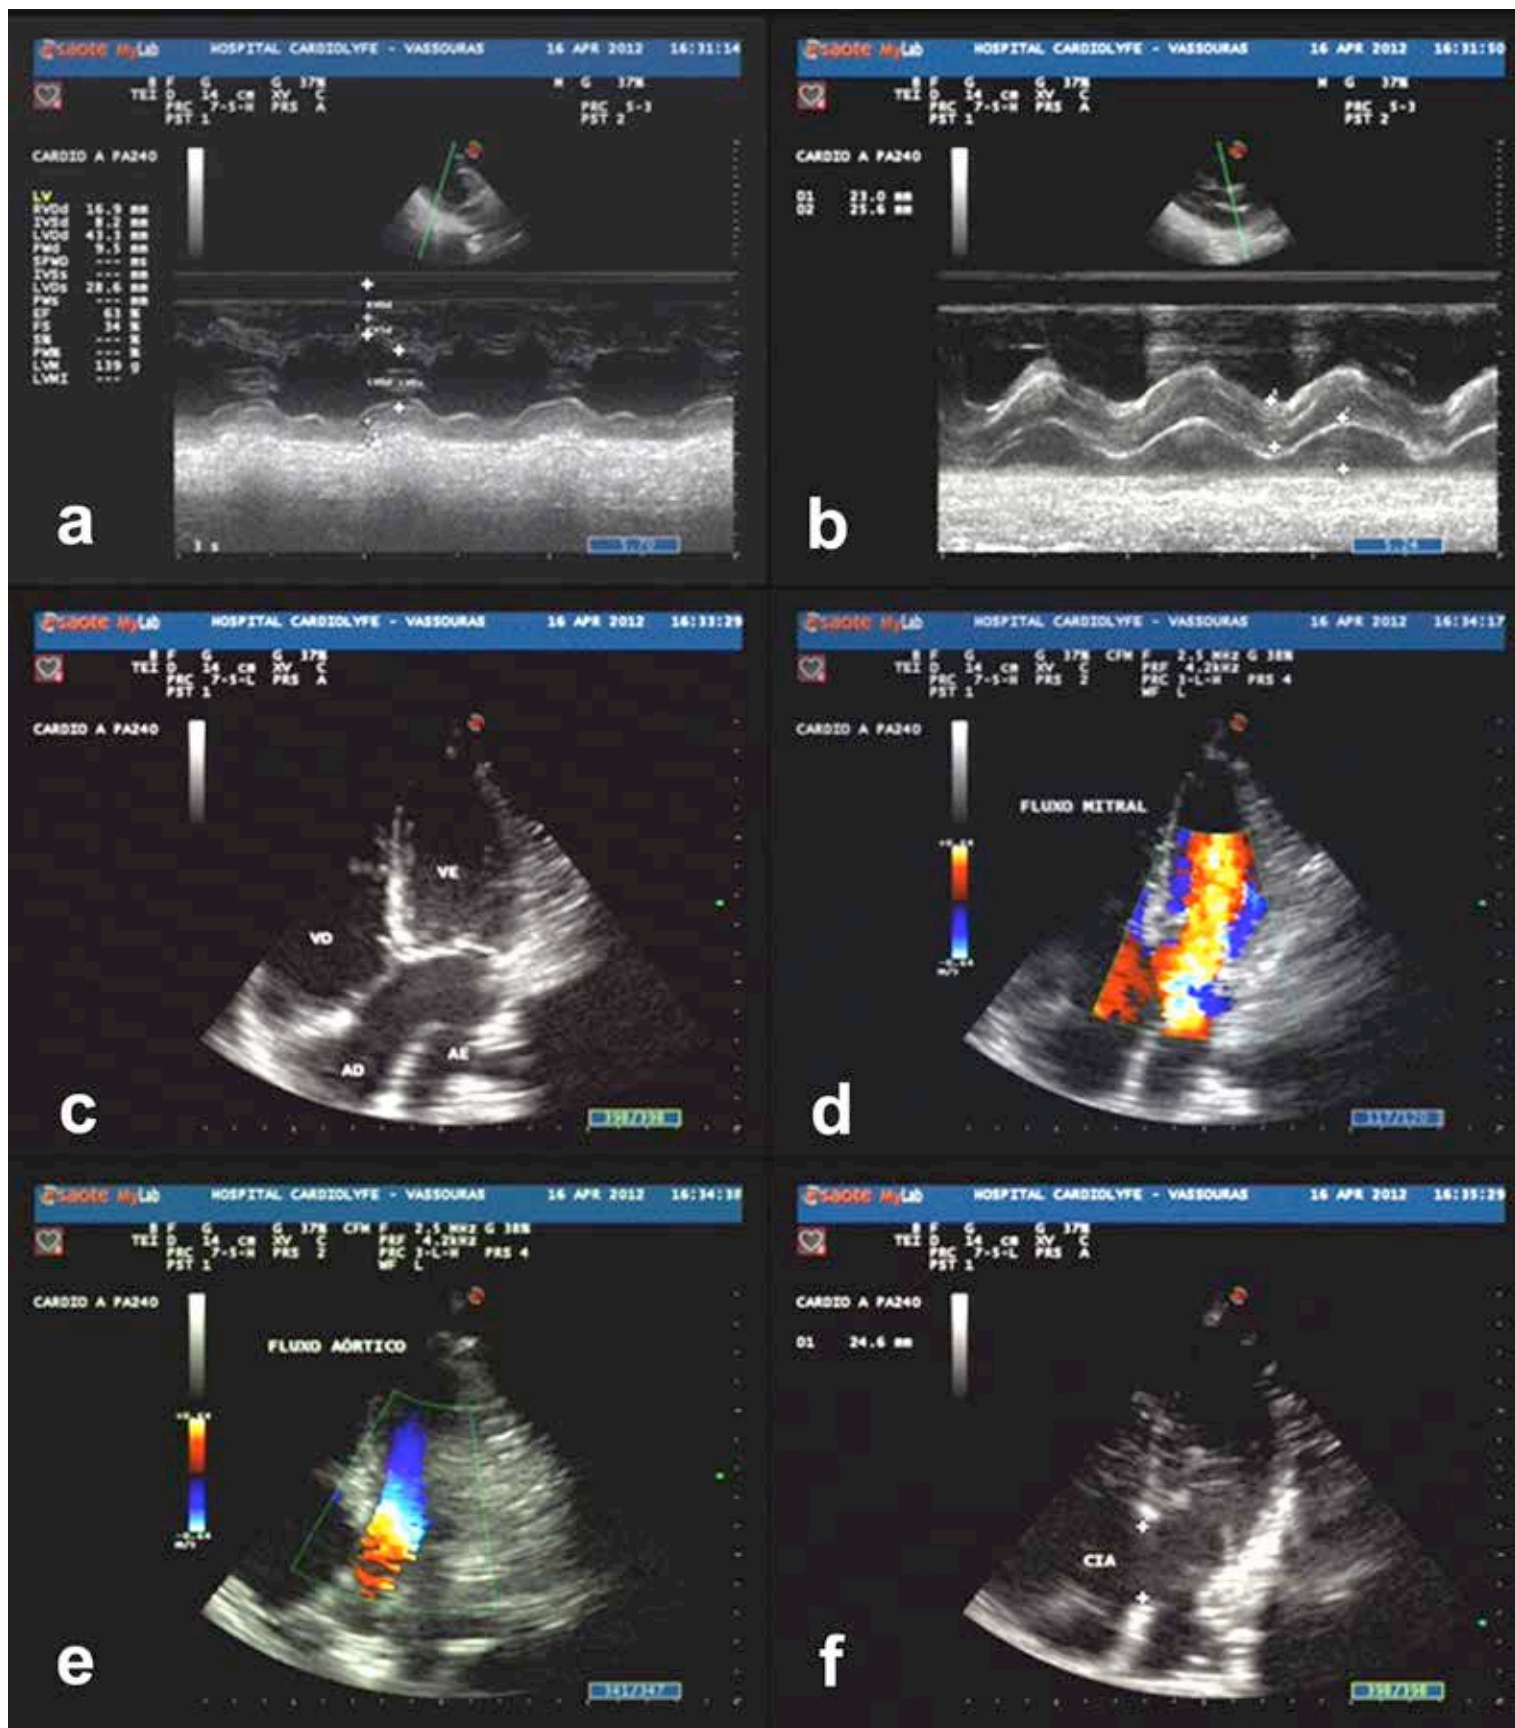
Echocardiogram with Color Doppler. A: M mode or unidimensional left ventricle longitudinal section. B: M mode or one-dimensional aorta and left atrium longitudinal section. C: Apical 4-chamber view. D: Mitral flow demonstrated by Color Doppler. E: Aortic flow demonstrated by Color Doppler. F: Interatrial communication visualization.
